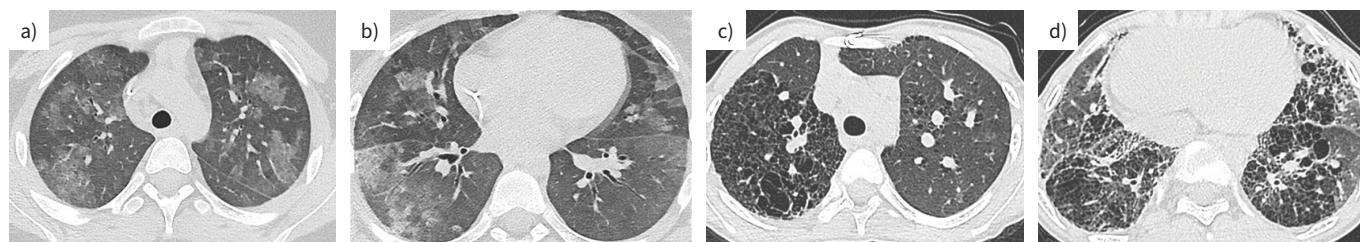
Computed tomography (CT) patterns associated with interferonopathies. a and b) CT scan of a 10-year-old girl with *COPA* syndrome showing bilateral ground-glass opacities with no specific area predilection. The opacities are sometimes confluent or associated with thickened interlobular septa and intralobular lines with a crazy paving appearance. Pattern suggestive of alveolar haemorrhage that led to the diagnosis of a *COPA* mutation. c and d) CT scan of a 14-year-old boy with *STING*-associated vasculopathy with onset in infancy showing a fibrosing interstitial lung in association with dry macular eruptions without loss of substance that led to the diagnosis of a *STING* mutation.
